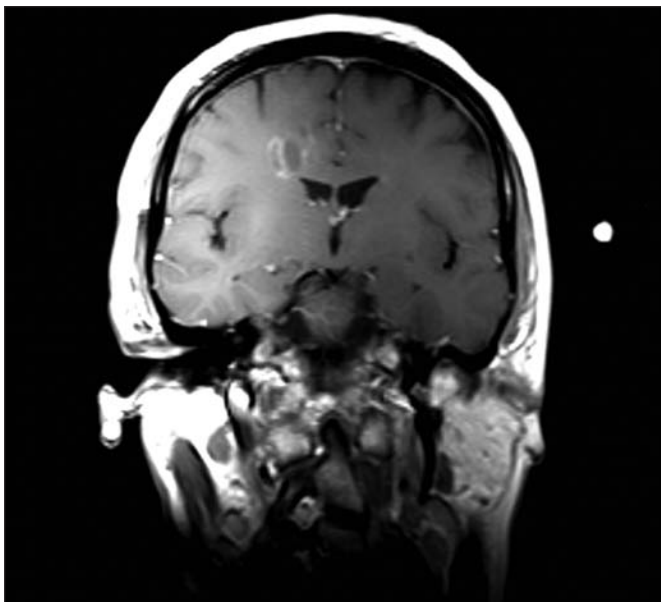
Axial T1-weighted post-gadolinium image showing a small focus of enhancement at the superomedial aspect of the lesion.
